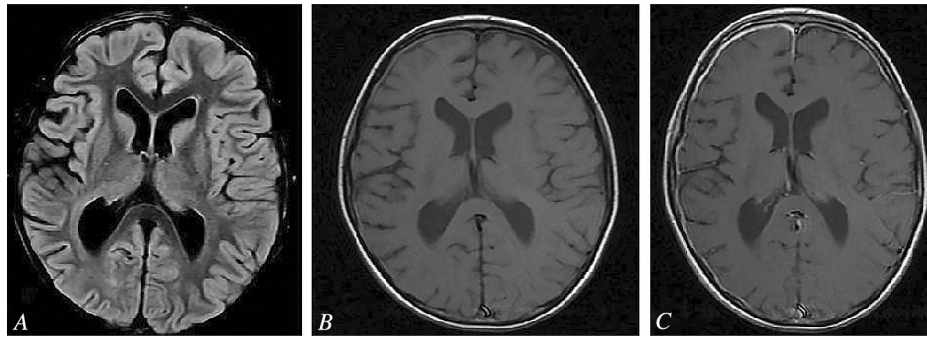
Changes on MRI brain scans in a patient with clinically confirmed acute purulent meningitis. FLAIR (A) and T1 (B) modes visualize minor thickening of the meninges in the right frontal area. Images in T1 mode with internal contrasting (C) show marked increases in signal from the meninges on the right in the frontal and parietal areas.
